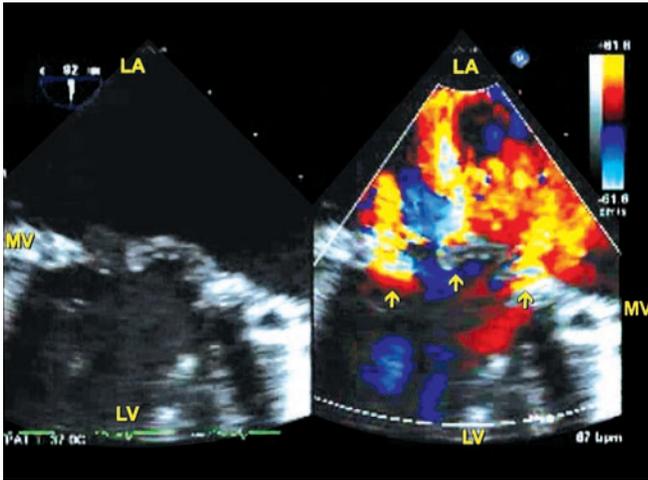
Transesophageal echocardiography with color Doppler demonstrates severe mitral insufficiency with three distinct jets of valvular MR (arrows) originating from within the annuloplasty ring. Two of the mitral regurgitation jets emerge (arrows) from two separate perforations or clefts of the posterior leaflet, one involving the P3 scallop and the other involving the P1 scallop.
